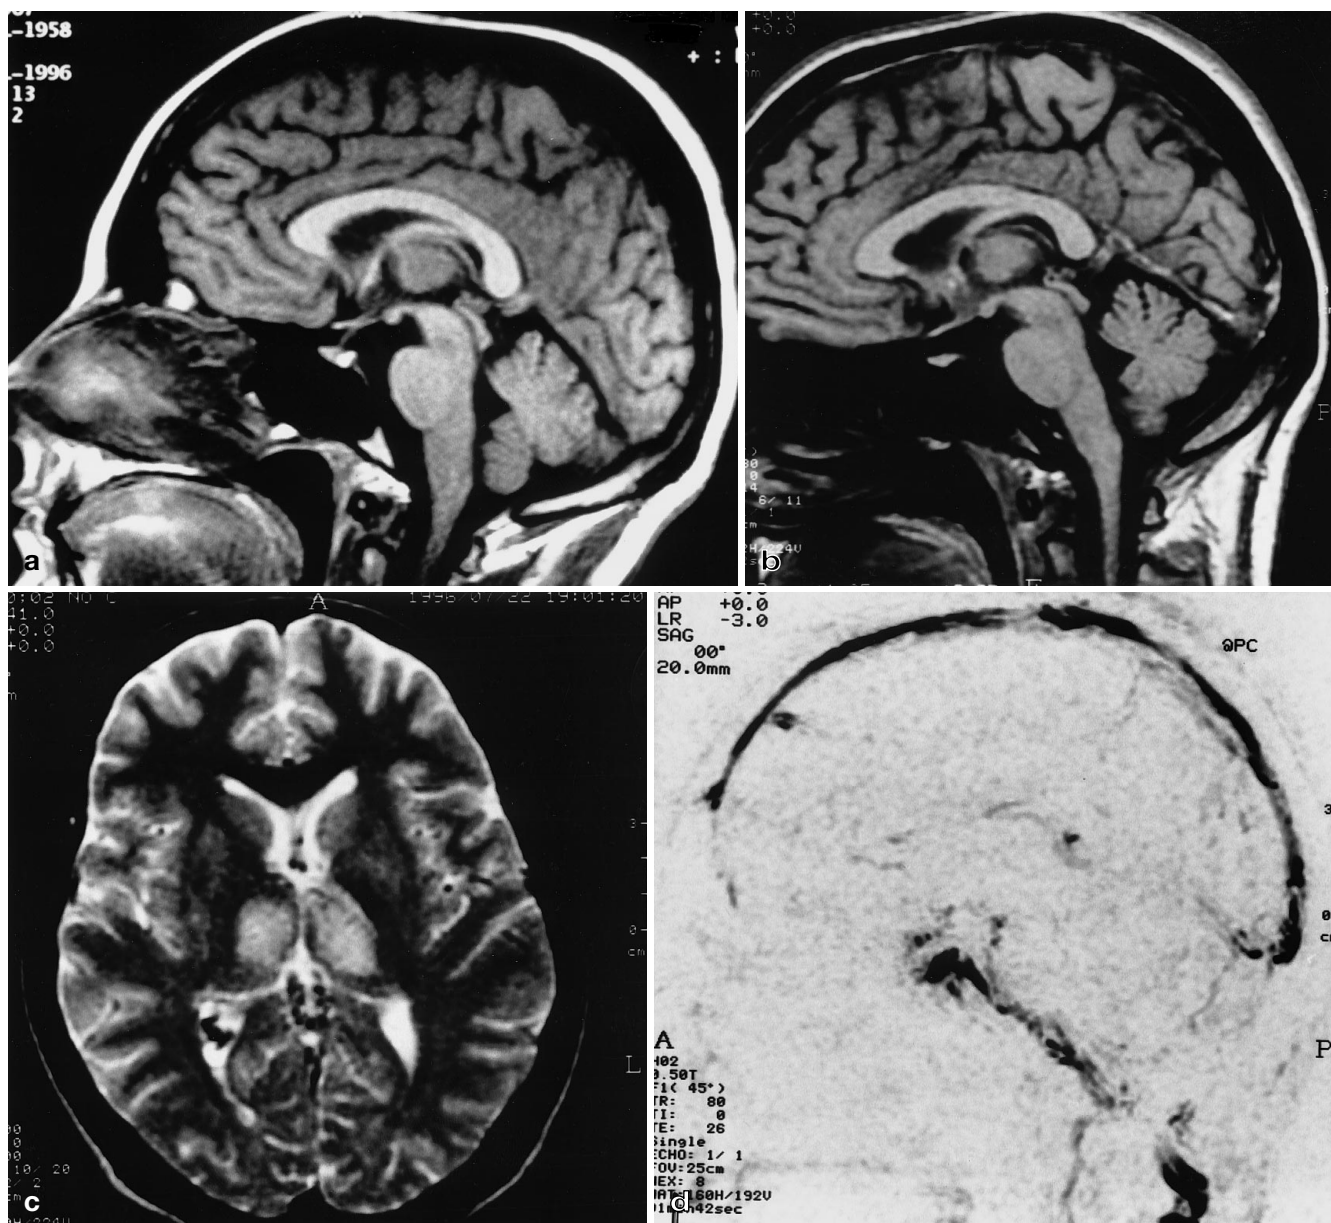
Case 6. a Sagittal T1-weighted image performed on day of onset shows isointense signal from the internal cerebral vein, vein of Galen, and straight sinus. b on day 3 there is high signal in the straight sinus and vein of Galen. c Axial T2-weighted image shows high in the thalamus and the posterior limb of the left internal capsule. d, e MRA (2D phase-contrast, midline sagittal) sagittal and coronal: the straight sinus is not seen; only the right internal cerebral vein is seen (*arrow*) in either planes. No flow is visible in the left lateral sinus. f Left carotid angiogram, lateral projection, shows no filling of the deep cerebral venous system. g T1-weighted left parasagittal image 14 days after onset shows partial recanalisation of straight sinus and complete recanalisation of the vein of Galen and internal cerebral vein
